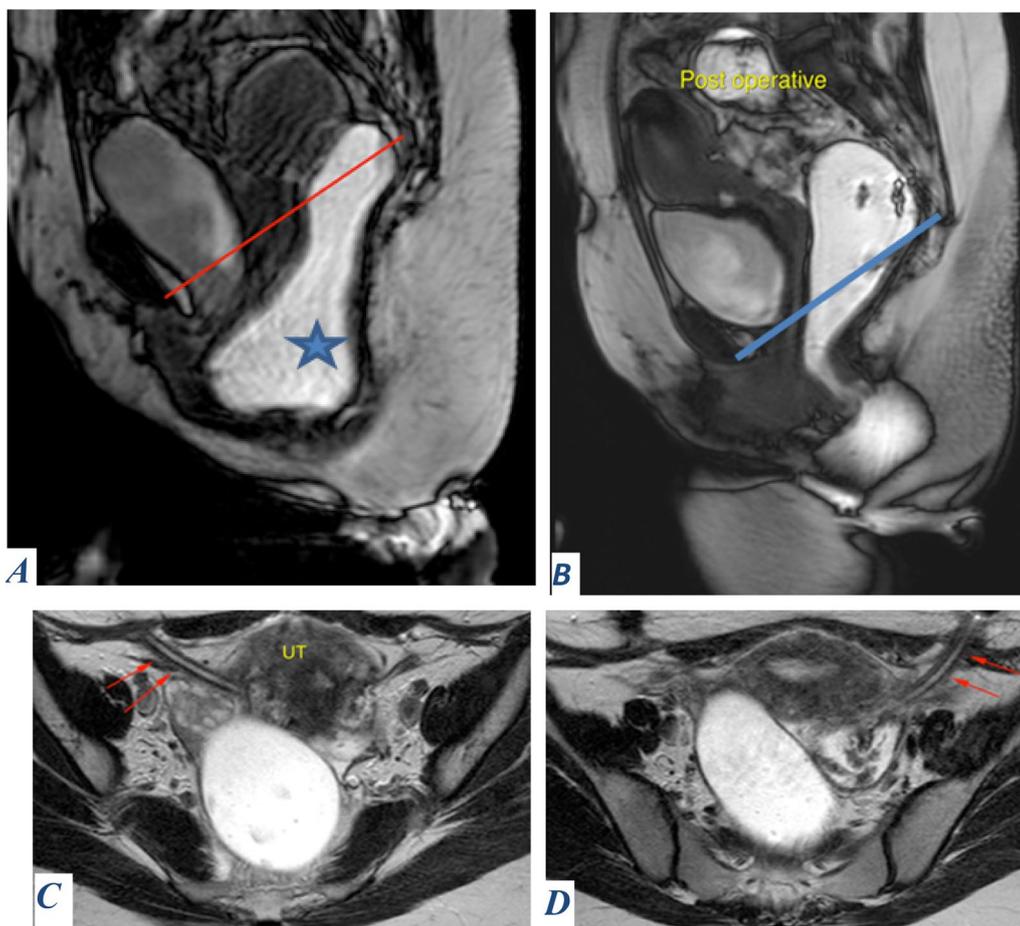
A 48-year-old lady referred with symptoms of multi-compartmental pelvic floor descent. She underwent uterine mesh placement and had a successful outcome. A Sagittal BFFE MRD during evacuation shows mild uterine descent below PCL (red line) and a rectocele (blue star). B Postoperative MRD showing no major organ prolapse below PCL delineated by the blue line. C, D Axial TW2 MR images showing right and left uterine mesh arms (red arrows) with no structural abnormalities and no surrounding collections or smudging of fat planes
